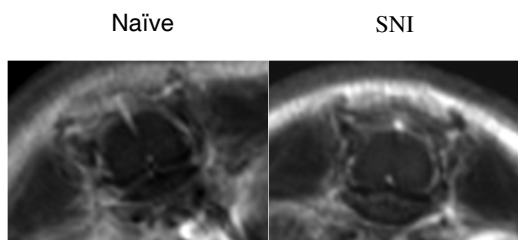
Representative coronal MRI scans through lumbar spinal cord
